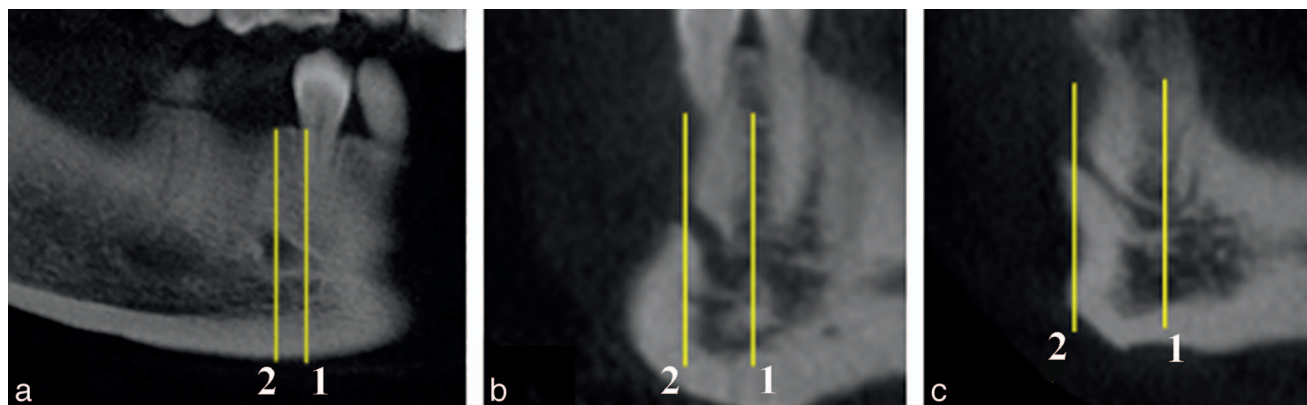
Cone-beam computerized tomography images of different patients reveal following anterior loop lengths: (a) 2.5 mm, (b) 4.8 mm, (c) 6 mm. The most anterior borders of the inferior alveolar canal curve (1) and the mental foramen (2) are indicated.
